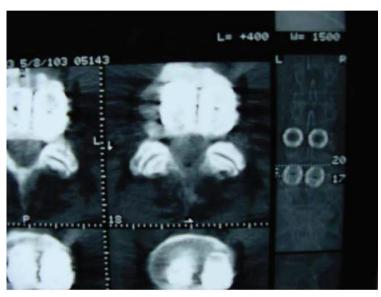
CT Scan of Older Titanium Fusion Cage Technology.
